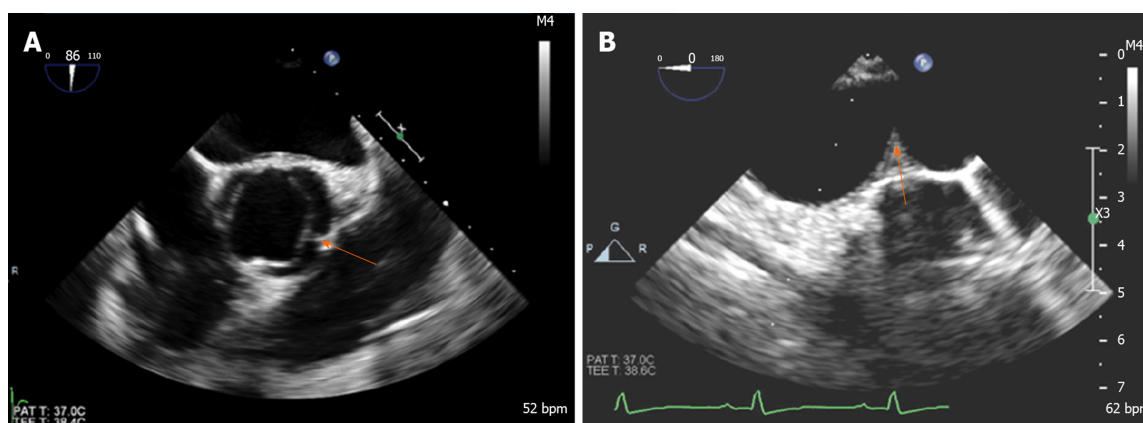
Transesophageal echocardiogram in a patient with coarctation demonstrating. A: Bicuspid aortic valve with raphe between left and right coronary cusps (arrow); B: Coarctation in distal aortic arch (arrow).
